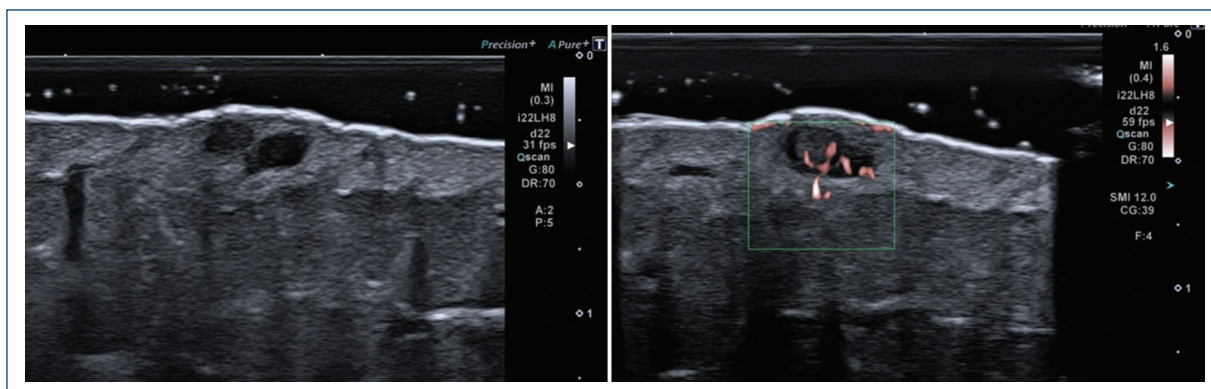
High-frequency ultrasound showing dermal lymphatic-like structures with increased flow on superb microvascular imaging, suggesting residual lesion activity.
